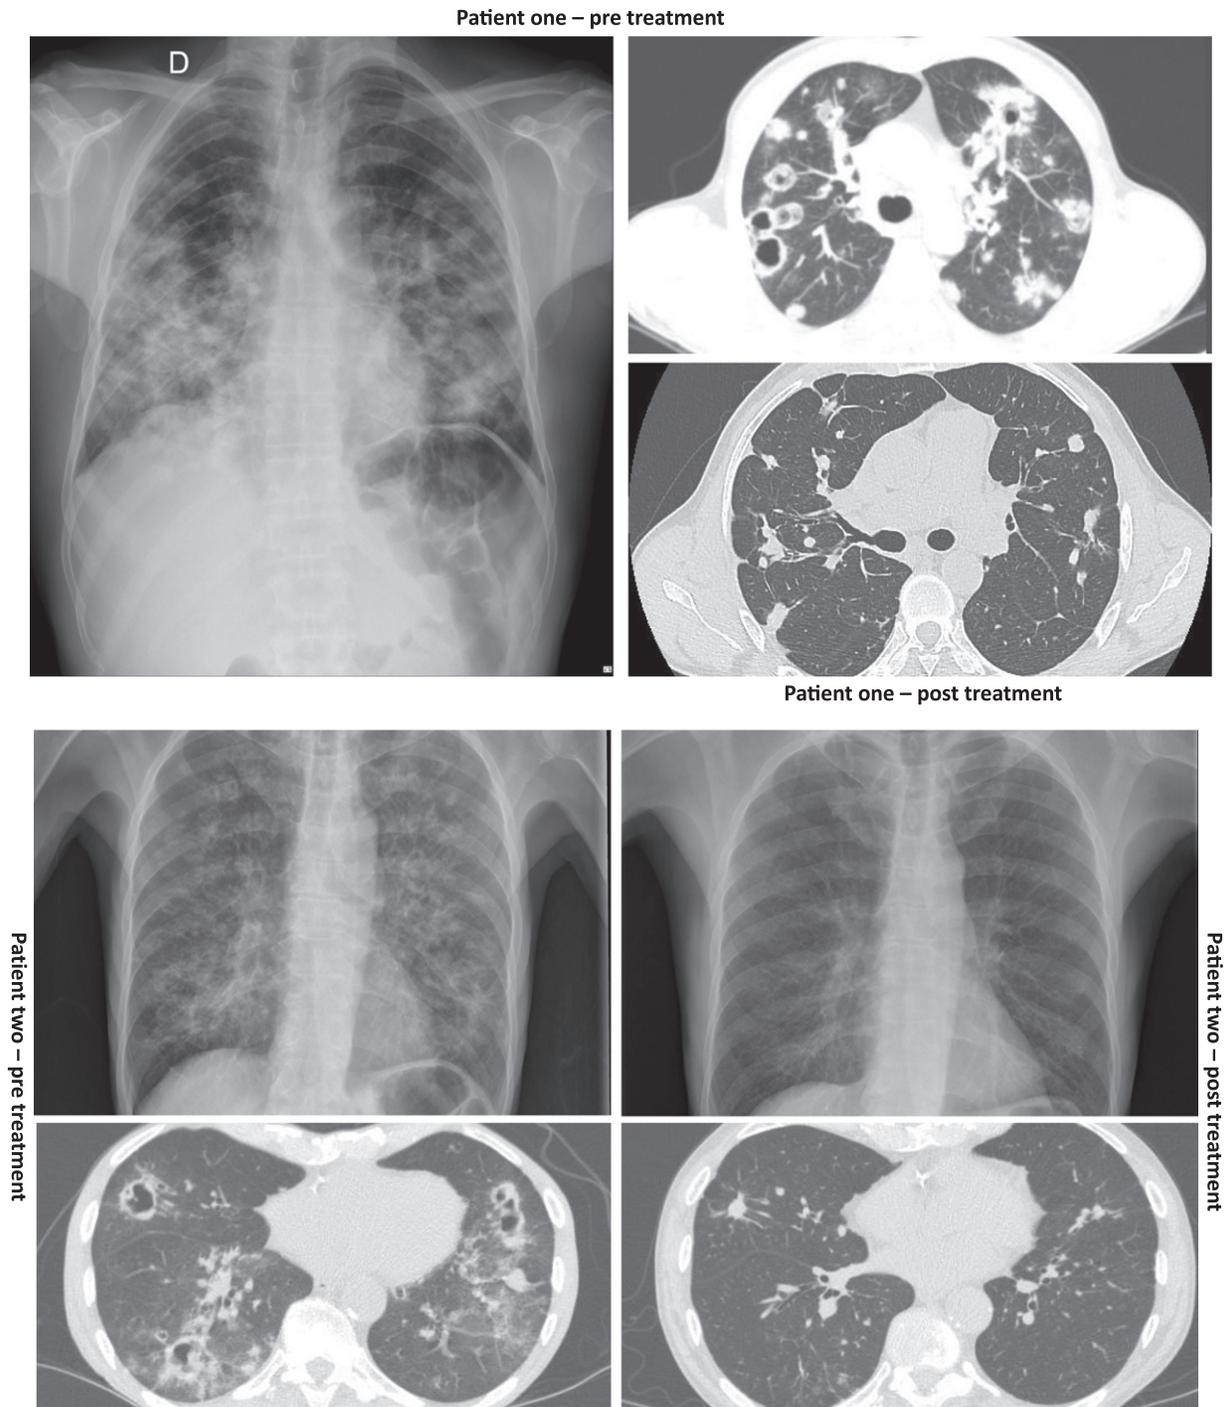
Typical pulmonary involvement in the chronic form of the disease. Patient one, chest X-ray (left) showing typical bilateral infiltrates on admission, and thoracic CT scans showing the parenchymatous lesions before (upper) and their improvement during antifungal therapy (lower). Patient two, on the left, chest X-ray showing typical bilateral infiltrates and thoracic CT scan showing the parenchymatous lesions on admission; on the right, chest X-ray and CT scan taken at the end of the antifungal therapy: note the presence of residual abnormalities such as small opacities and nodules, fibrosis, bronchial thickening and small area still with ground glass aspect.
